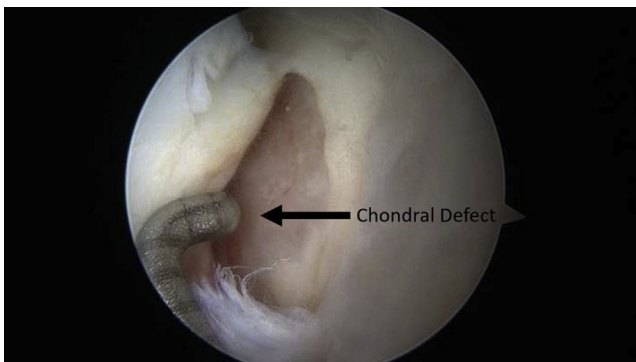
Chondral delamination defect covered by a cartilage flap that was incompletely characterized on preoperative magnetic resonance imaging (view of left hip through midanterior portal).
